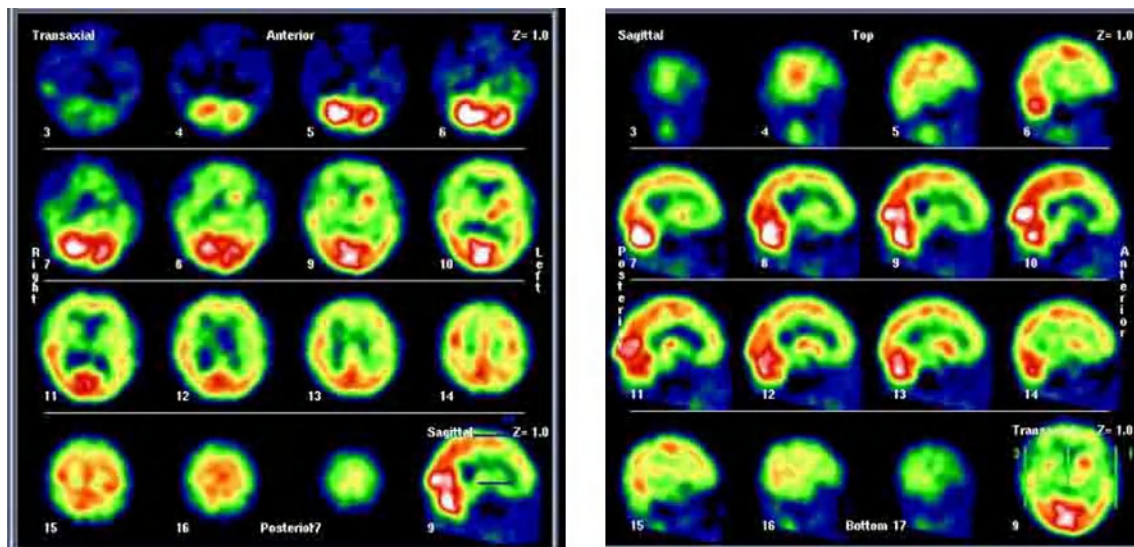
Brain blood flow SPECT
